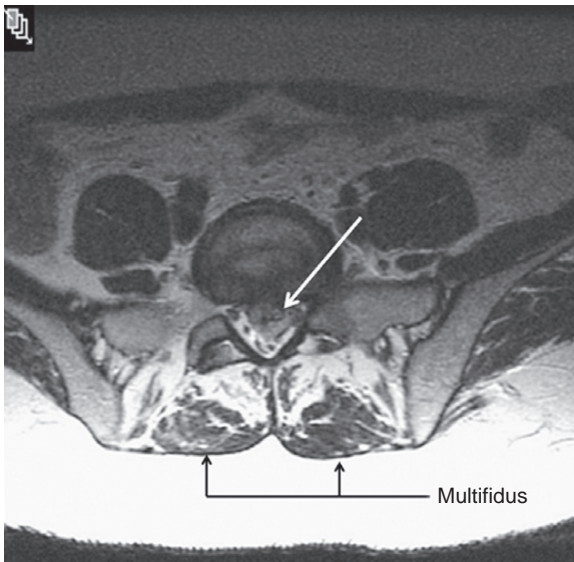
T2-weighted image of central disc bulge (arrow) at L5/S1. Note the difference in the size and composition of the multifidus. In low back pain the multifidus has been shown to shut down side and level specific and do not spontaneously return after surgery.
